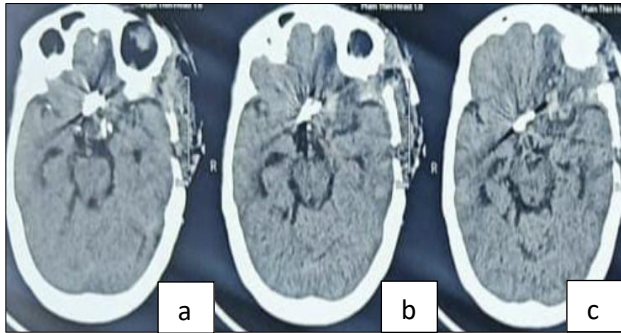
(a-c): Post-operative radiographic images.
